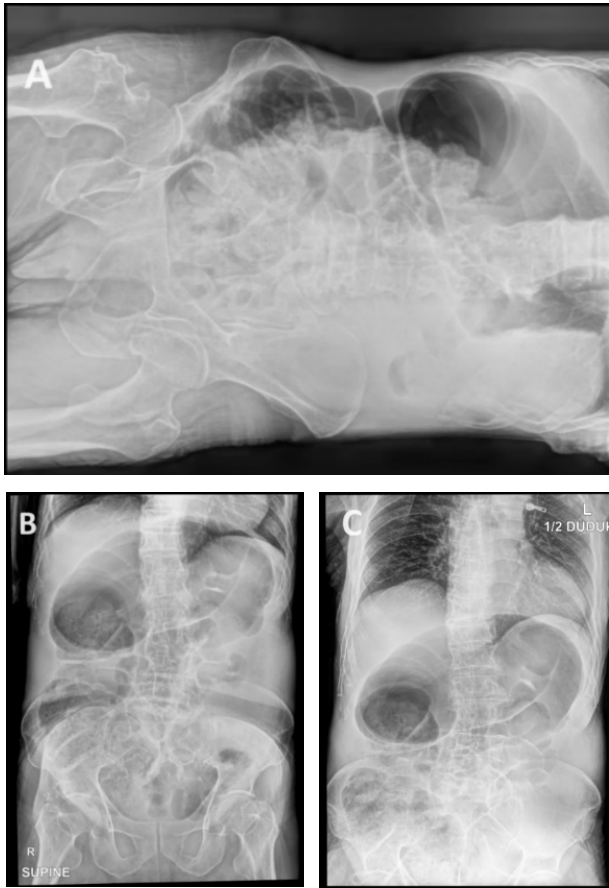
A 3-position abdominal x-ray shows colon and partial small bowel dilatation, indicating large bowel obstruction. The largest measured colon diameter is 10.94cm
